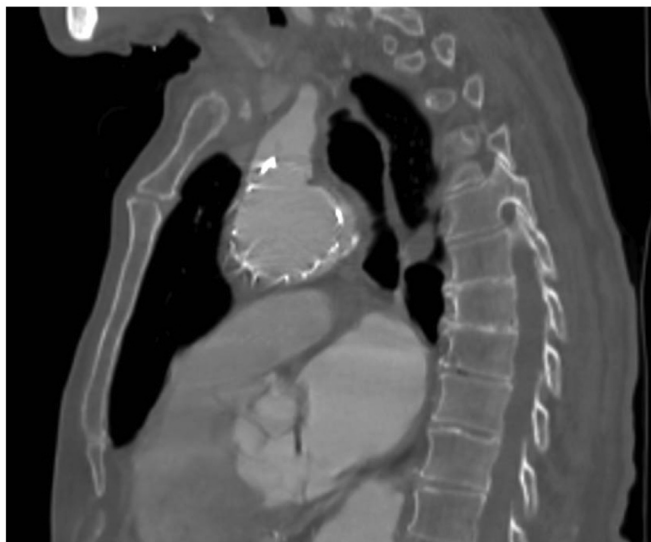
Two-week follow-up computed tomography angiogram (CTA) demonstrating adequate patency of the innominate artery.
